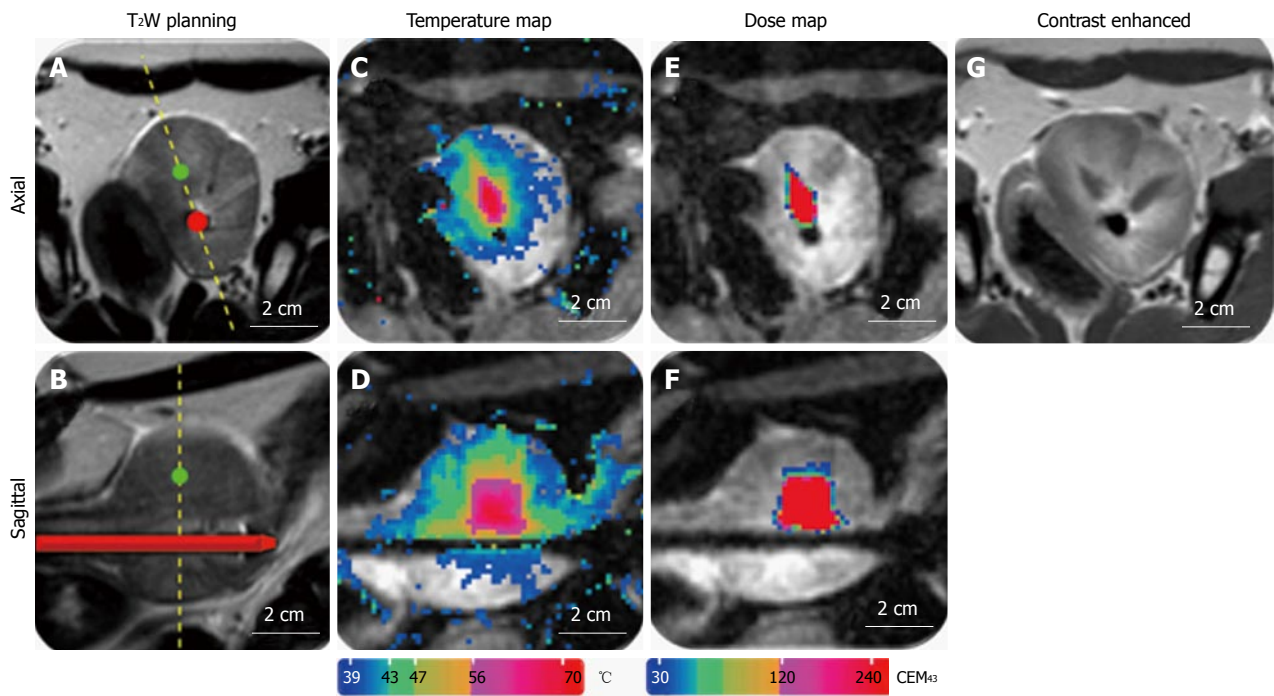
Representative images of magnetic resonance imaging-guidance. A: T₂-weighted image for positioning and treatment planning in axial and sagittal orientation (B); C: MR temperature map during ultrasound treatment in axial and sagittal orientation (D); E: MR dose map during ultrasound treatment in axial and sagittal orientation (F); G: Contrast enhanced T₁-weighted image after ultrasound treatment. MR: Magnetic resonance.
